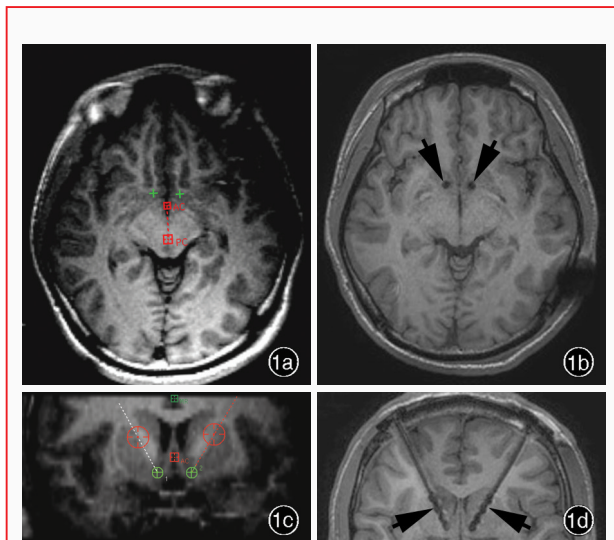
伏隔核联合内囊前肢电刺激术的 MRI 检查所见
